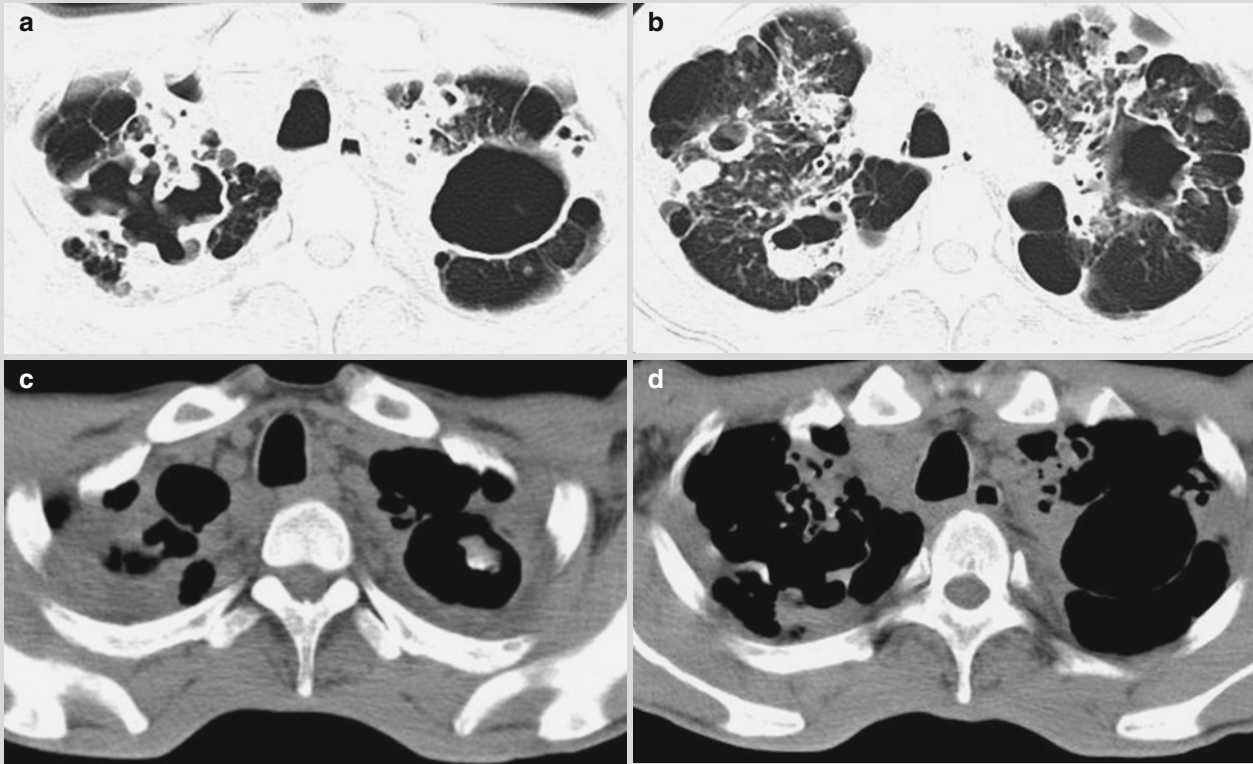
Chronic fibro-cavity pulmonary TB. (a–d) CT scanning demonstrates multiple thick wall cavities at the upper lobe of both lungs, accompanying bronchial lesions due to dissemination, and pleural thickening
